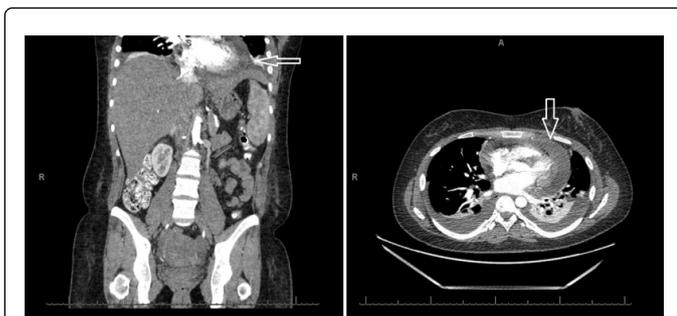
Subsequent CT of abdomen and pelvis 3 days later demonstrates an enlargement of the pericardial effusion (white arrow) with mild rim enhancement along the pericardium. Hepatosplenomegaly are again demonstrated.
